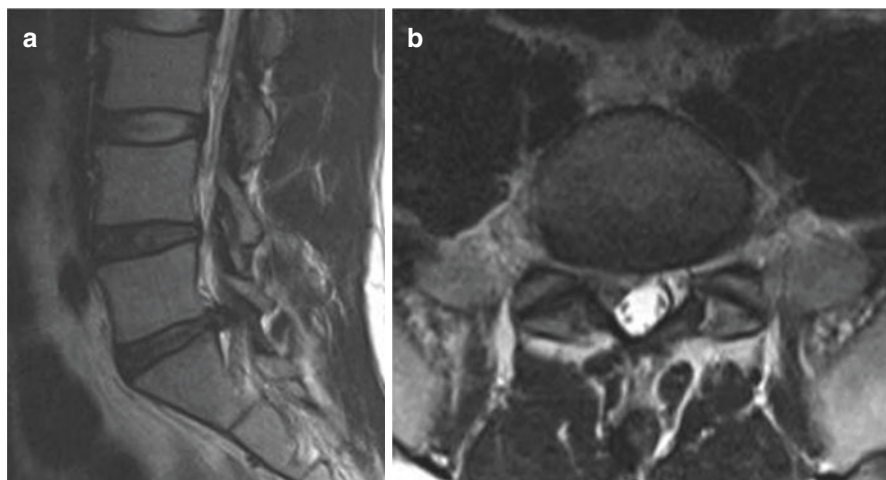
(a) Preoperative MRI L spine T2 sagittal shows a disk herniation at the L5–S1 level. (b) MRI L spine T2 axial view shows a right lateralized disk herniation with effacement of the thecal sac and resultant foraminal stenosis
